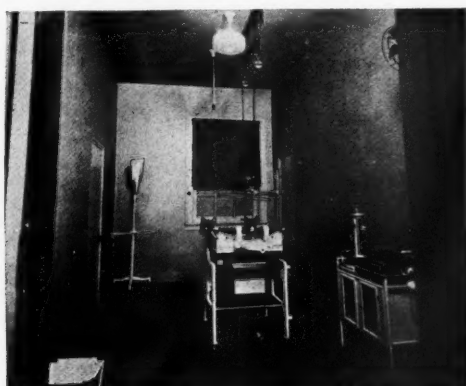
Cystoscopic room. Note high tension terminals projecting through ceiling. X-ray apparatus is on the floor above.
